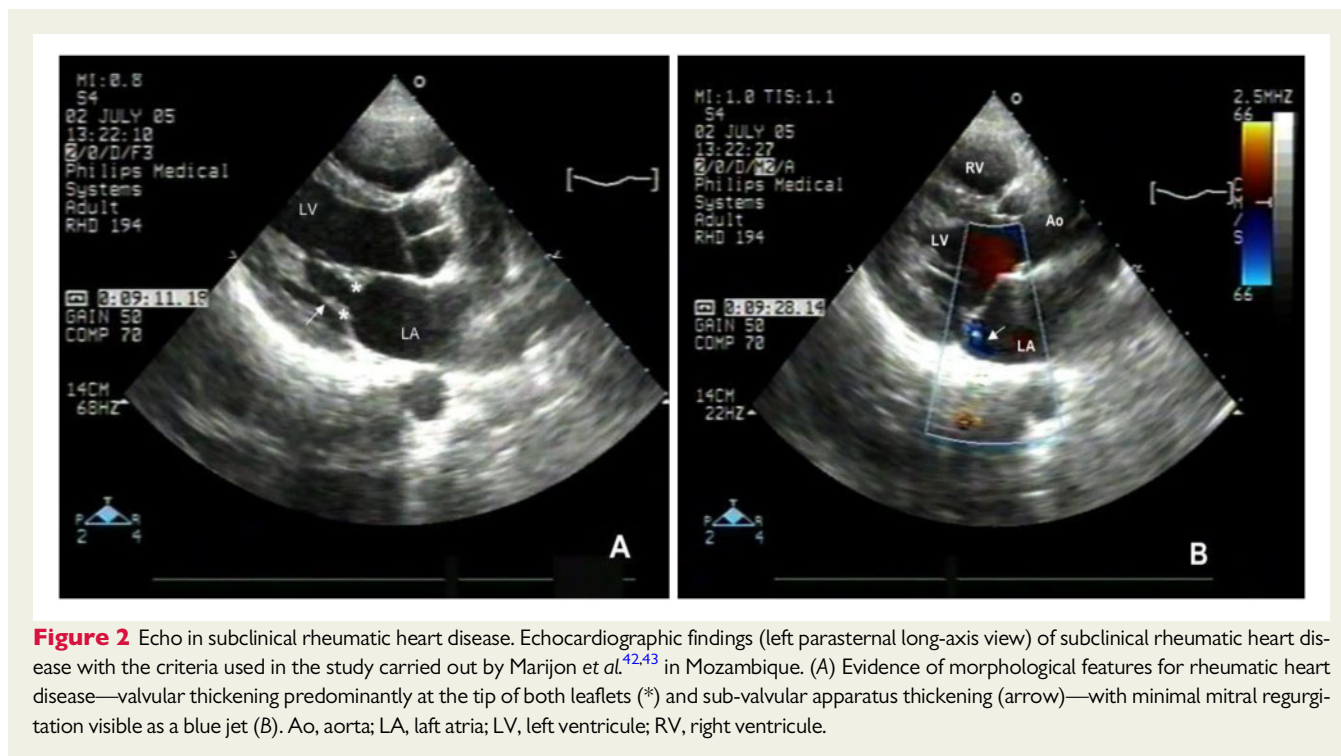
Echo in subclinical rheumatic heart disease. Echocardiographic findings (left parasternal long-axis view) of subclinical rheumatic heart disease with the criteria used in the study carried out by Marijon et al.^{42,43} in Mozambique. (A) Evidence of morphological features for rheumatic heart disease—valvular thickening predominantly at the tip of both leaflets (*) and sub-valvular apparatus thickening (arrow)—with minimal mitral regurgitation visible as a blue jet (B). Ao, aorta; LA, left atria; LV, left ventricle; RV, right ventricle.
